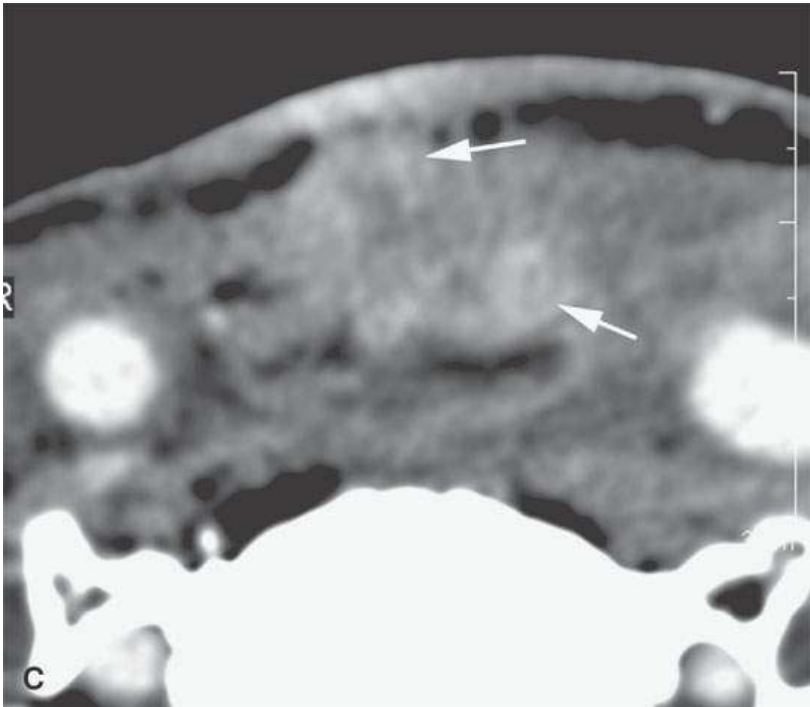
Contrast-enhanced computed tomography of two patients with neopharyngeal recurrence. A: Patient 1 with a relatively normal-appearing neopharynx except for a nodule of recurrent tumor (black arrow). The patient presented with dysphagia. B, C: Patient 2. In (B), a relatively extensive infiltrating mass involves the residual thyroid gland and anterior wall of the neopharynx (arrows). The carotid artery (arrowhead) is free of disease. In (C), multifocal areas of involvement are present at another level (arrows).
